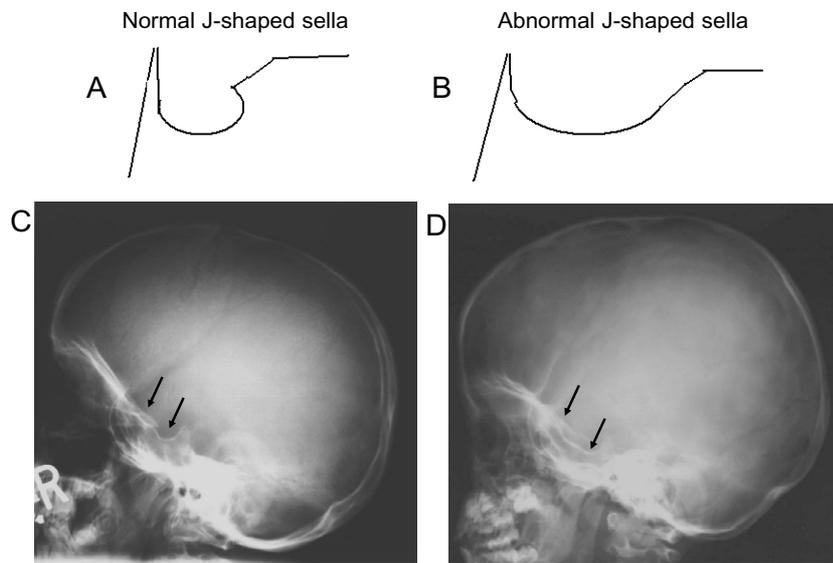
Manifestations of dysostosis multiplex in the skull. (A) normal J-shaped sella turcica, (B) abnormal J-shaped sella typical for MPS. Radiographs showing (C) the skull of a patient with normal diploic plates and mildly abnormal J-shaped sella (arrows), and (D) the skull of a patient with thickened diploic plates and severe J-shaped sella (arrows)
